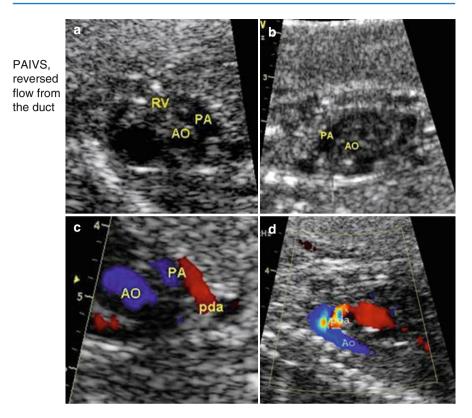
Two-D echocardiographic images (a and b). Case with pulmonary atresia and intact septum (PAIVS) and reversed pulmonary flow from the duct at color Doppler – in *red* (c, d). *PA* pulmonary artery, *Ao* aorta, *pda* ductus arteriosus
